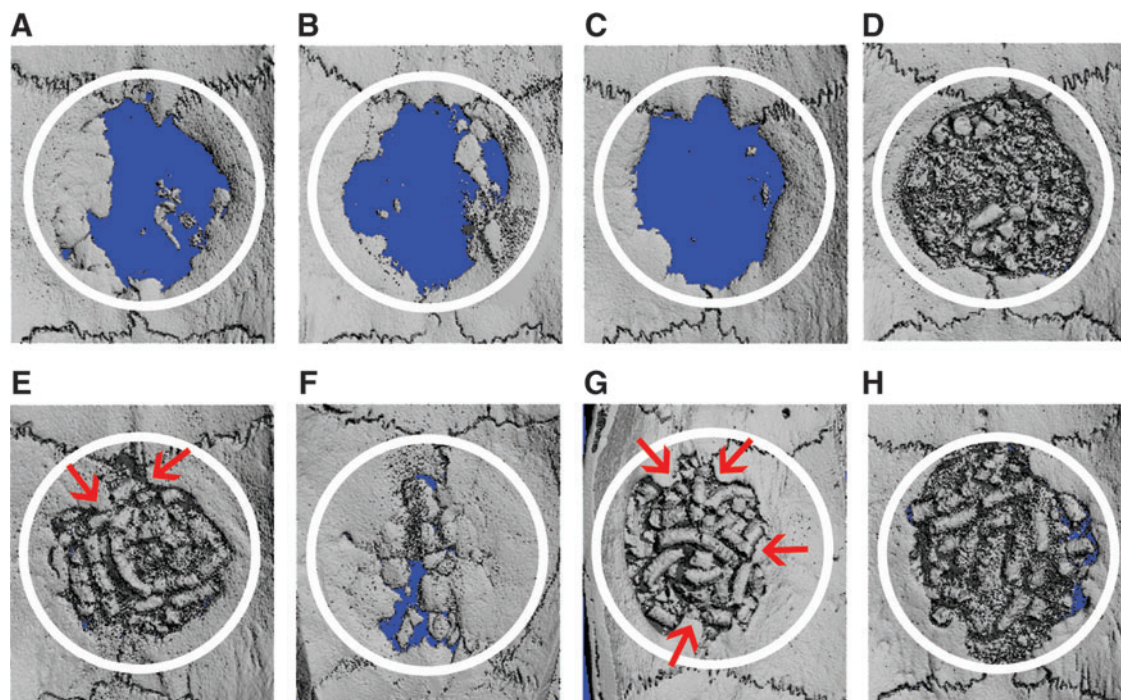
Three-dimensional μ CT view of calvaria defects (ventral aspect) 12 weeks postimplantation. (A) Empty defect-G1; (B) PLGA-G2; (C) collagen-G3; (D) HAP-GEL-G4; (E) TiO₂-HAP-GEL-G5; (F) bone autograft-G6; (G, H) TiO₂-HAP-GEL scaffold with: (G) OD-MAPCs-G7; and (H) MAPCs-G8. White circle represents the limits of the 8-mm-diameter defect area. Red arrows: regions of osteointegration. Color images available online at www.liebertpub.com/tea
